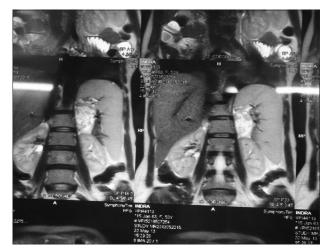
Coronal T2-weighted magnetic resonance imaging showing left suprarenal mass
